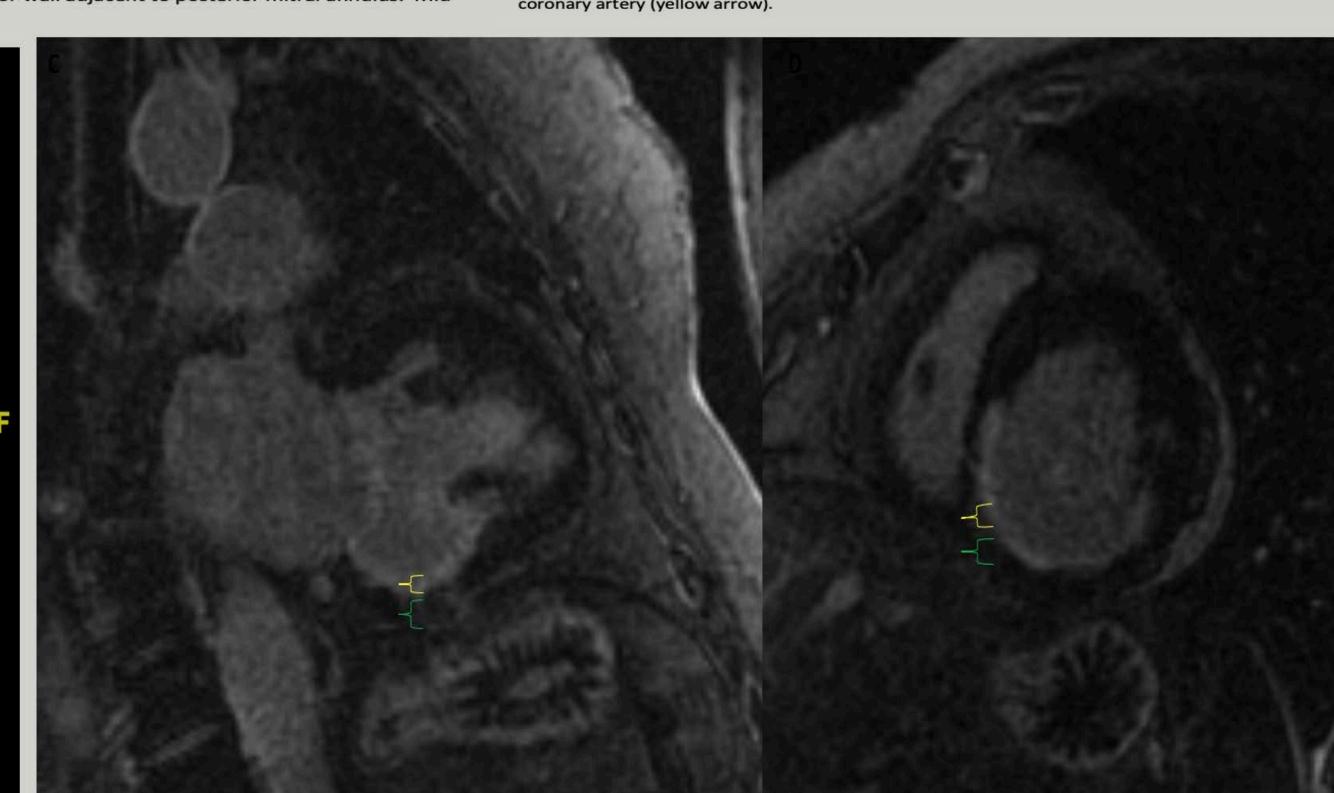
Cardiac magnetic resonance imaging with gadolinium myocardial delayed enhancement (MDE) – Aneurysmal outpouching identified as posterior true LV aneurysm with MDE involving the inferior and inferospetal myocardial segments, consistent with infarction in the distribution of the distal RCA. MDE imaging in the 2-chamber view (5C) demonstrated enhancement of 40% of the myocardial thickness of the inferior segments (yellow bracket, green bracket is non-infarcted myocardium). MDE imaging in the short axis view demonstrated enhancement of 70% of the inferoseptal myocardial thickness (yellow bracket).
